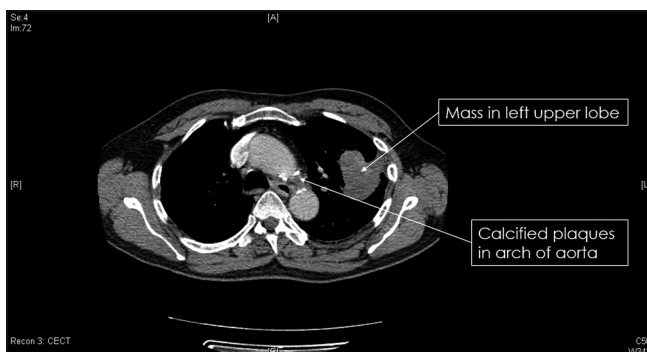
Chest CT scan showing left upper lobe mass
